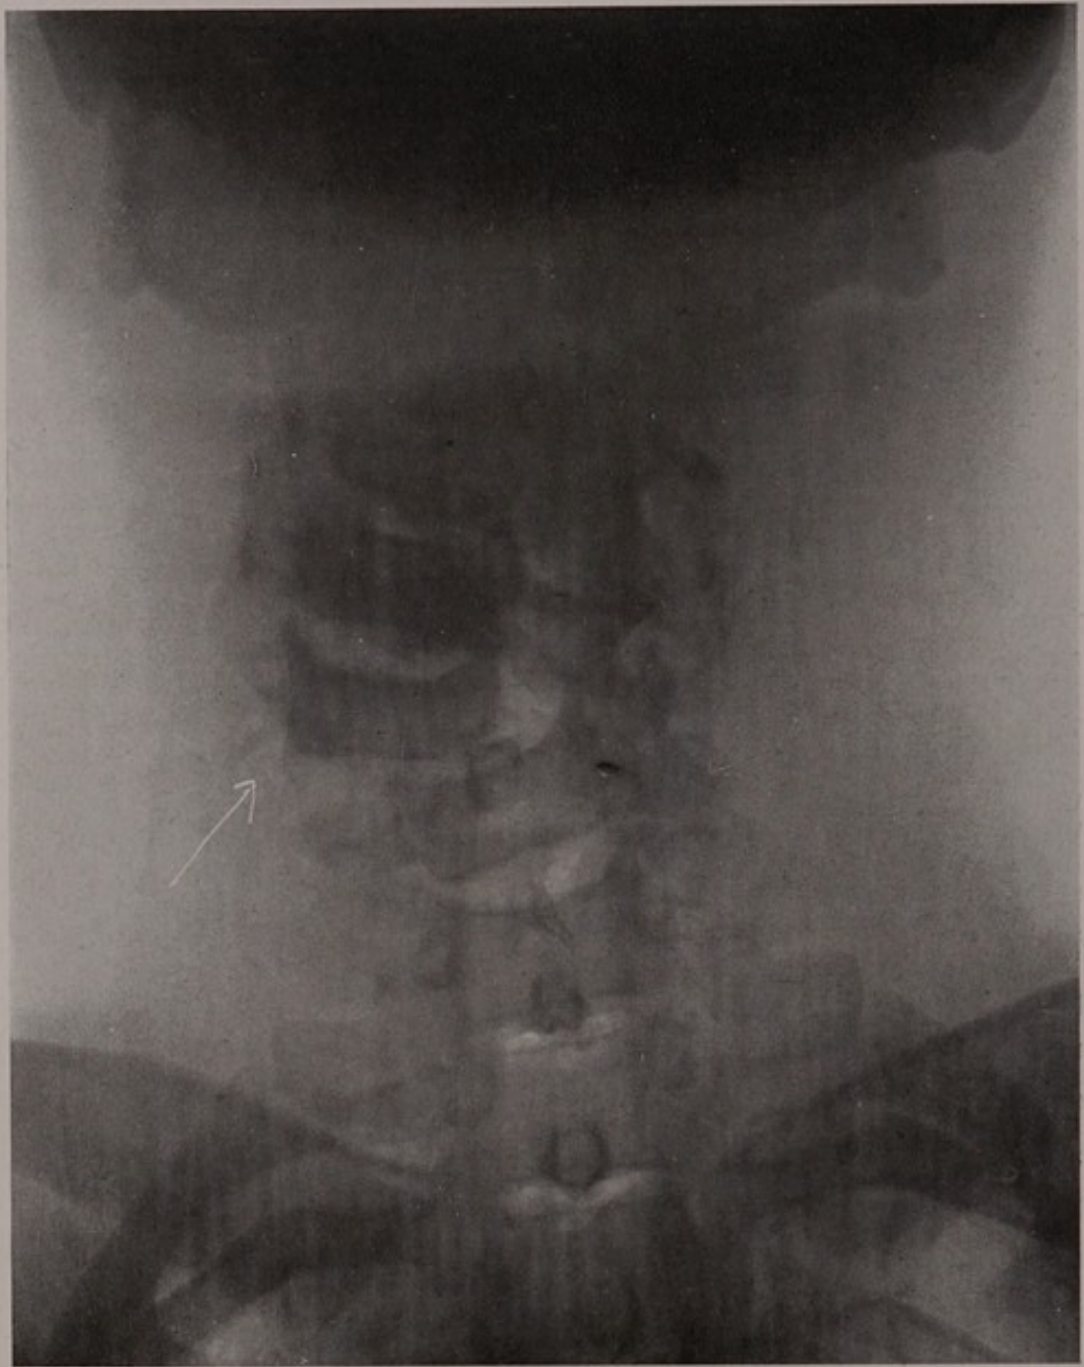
a*.—X-ray of fracture dislocation of the fourth and fifth cervical vertebræ. The patient was a professional high diver who fell a distance of 80 ft. He presented no symptoms excepting stiffness of the neck and slight weakness of the right arm. (I am indebted to Dr. Ernest Fahnestock for permission to use this and the following plate.)
